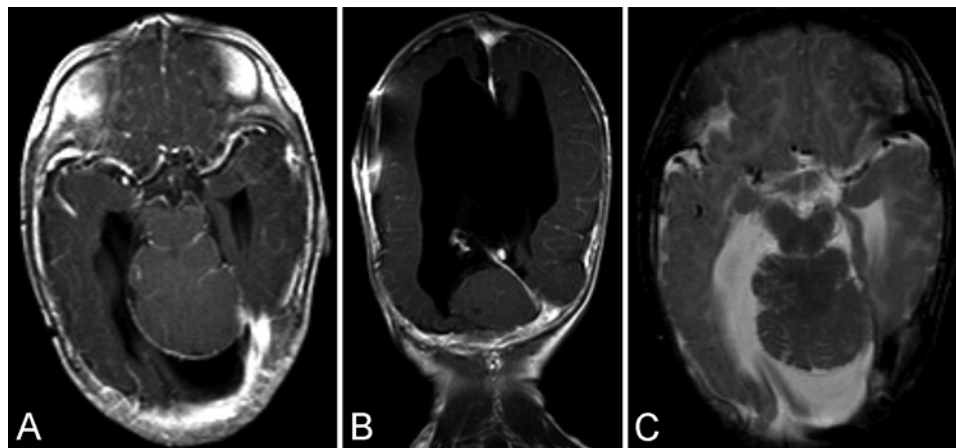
Case 4. A: Axial Gd-enhanced T1-weighted image showing complete fusion of the cerebellar hemispheres, without a discernible vermis. B: Coronal Gd-enhanced T1-weighted image demonstrating fused cerebellar hemispheres in addition to enlarged, irregular lateral ventricles, absence of the septum pellucidum, overall paucity of supratentorial white matter, and callosal dysgenesis. C: Axial T2-weighted image demonstrating fused cerebellar hemispheres extending across midline without a discernible vermis. Note the partially visualized lateral ventriculomegaly, due in part to diminished supratentorial white matter.
